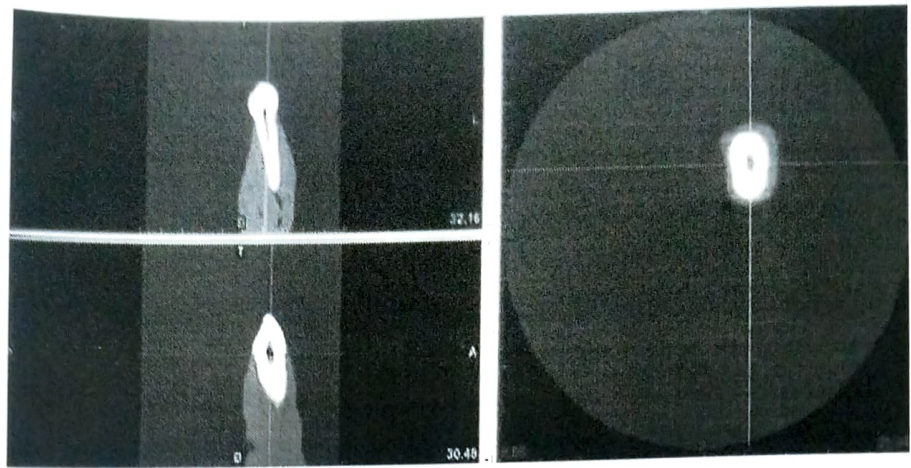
CBCT scans for the FEA
